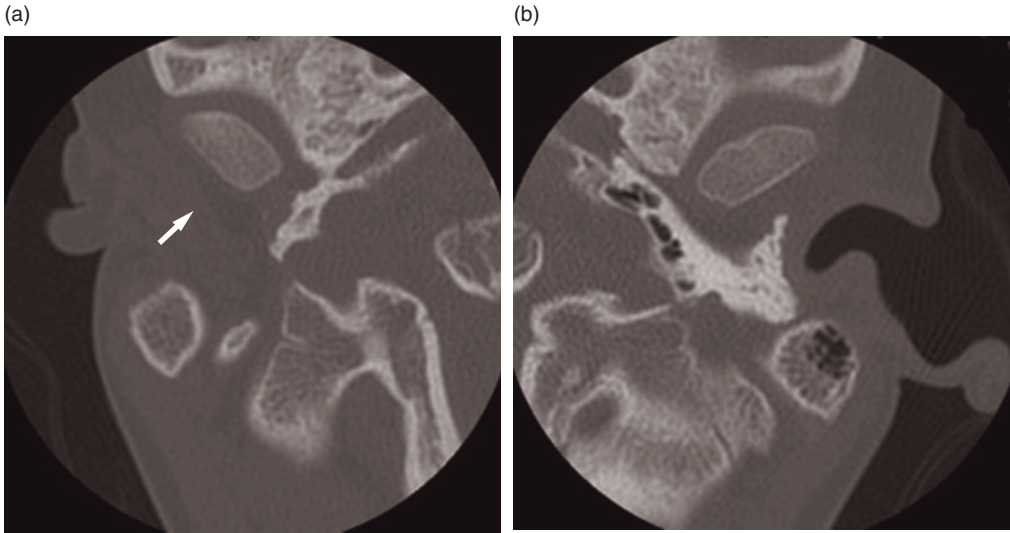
Axial CT scan. Microtia and absence of the posterior wall of the glenoid cavity (arrow) on the right (a), normal EAC and glenoid cavity on the left (b).
